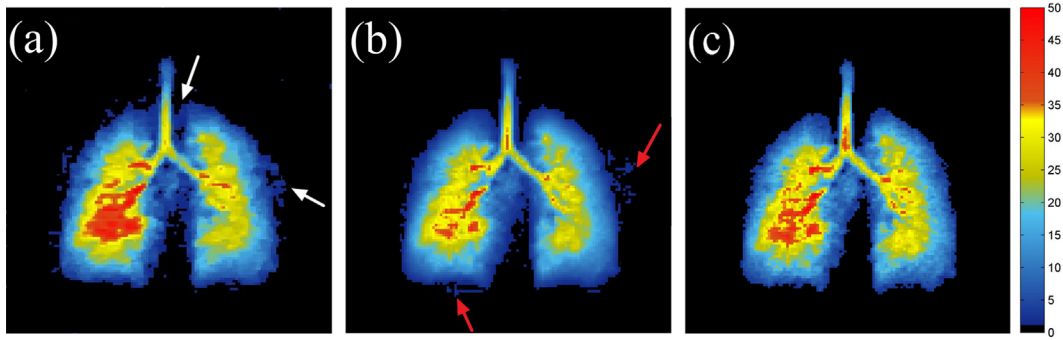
The 14th frame of *in vivo* dynamic HP ¹²⁹Xe MR images reconstructed using (a) the SRCS, (b) L + S and (c) L + S + G algorithms.
